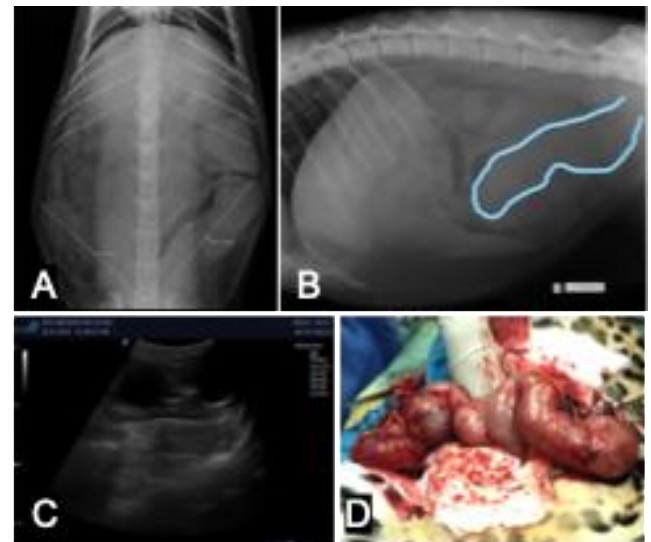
Clinical symptoms observed in Manja, a 17-year-old female leopard (*Panthera pardus*) kept in Zoo Negara, Malaysia. (A) Radiography imaging shows a tubular structure with soft tissue radiopacity; (B) Craniodorsally displaced intestines; (C) Ultrasonography imaging shows anechoic enlargement of the uterus; (D) A distended uterus observed during the ovariohysterectomy procedures.
